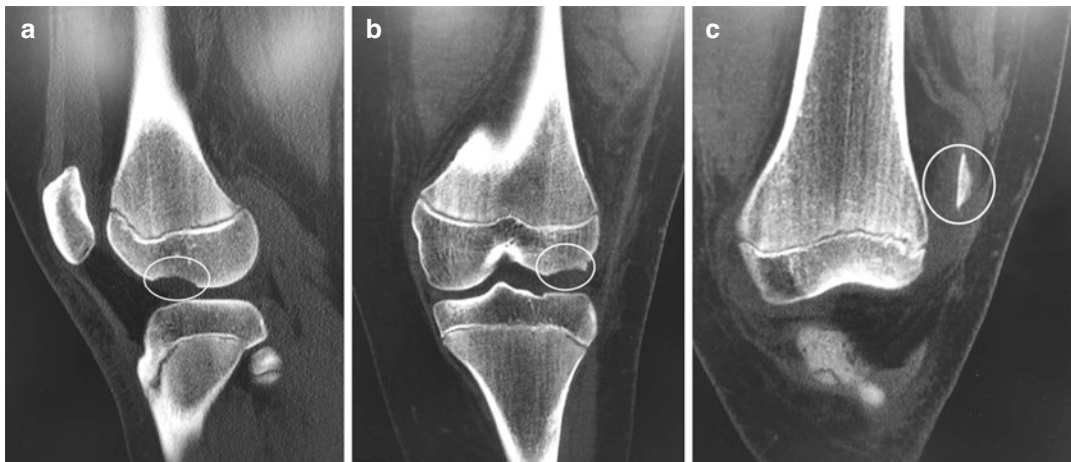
Sagittal (a) and Coronal (b) cuts of the CT scan demonstrating osteochondral donor site on the lateral femoral condyle and associated cartilage fragment in the lateral joint recess on an anterior coronal slice (c)
